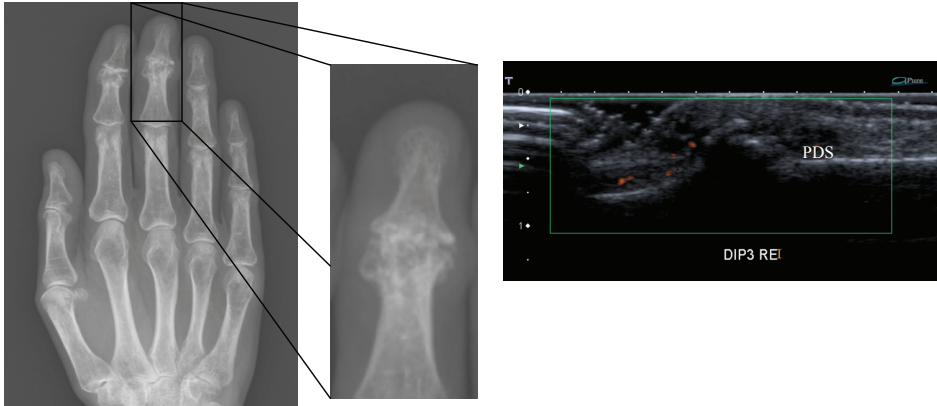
Images of erosive distal interphalangeal joint of the right hand. On the right the radiograph with in the window the affected joint, on the left the US image. Synovial thickening with power Doppler signal, and osteophytes grade 3 are depicted.
